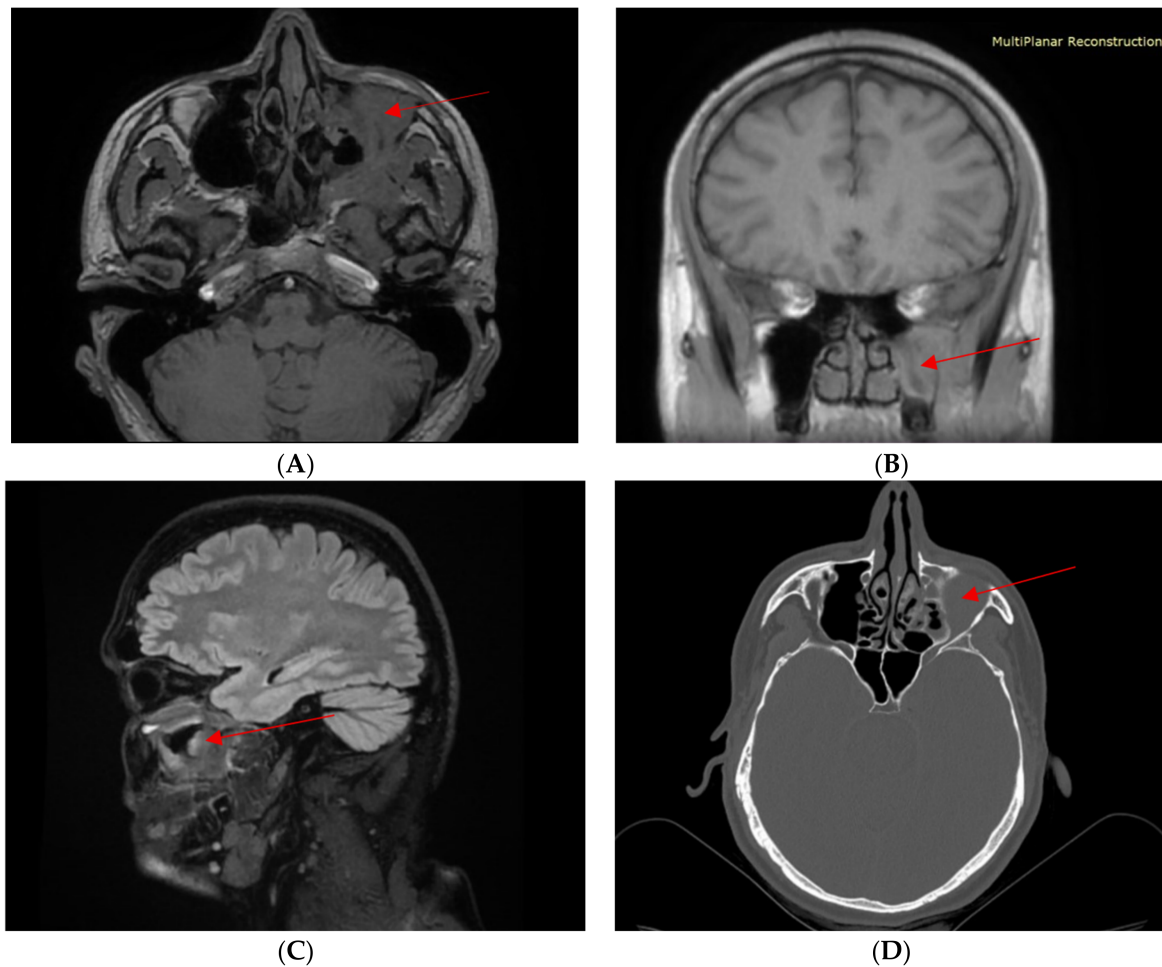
MR imaging (A–C), CT scan (D). Red arrows showing the fibroinflammatory mass invading the left maxillary sinus.
